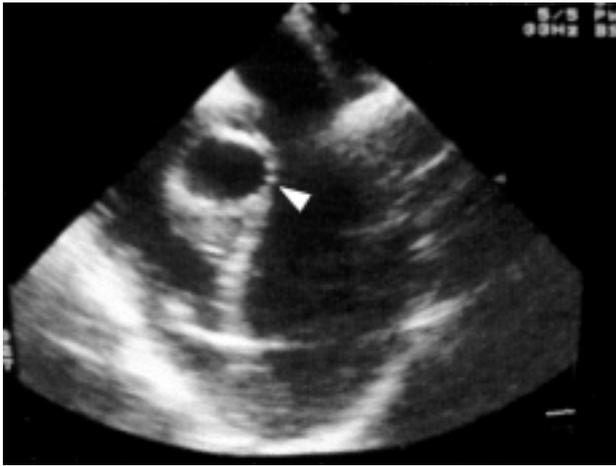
Intraoperative transesophageal echocardiography showing the cardiac cyst located in the proximal interventricular septum (arrow).
